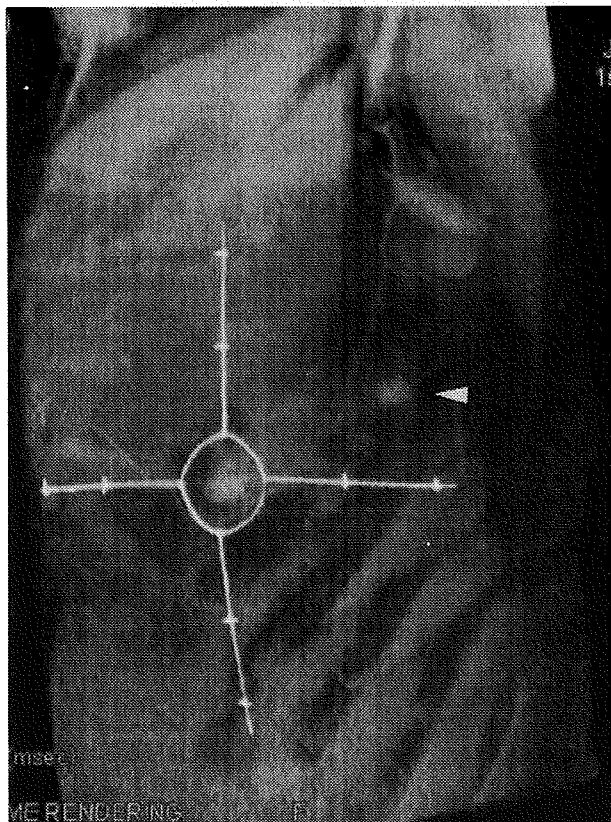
3D CT revealed the tumor about 1.3 cm in size corresponding to the same site noted on PET-CT (*white arrow*)
